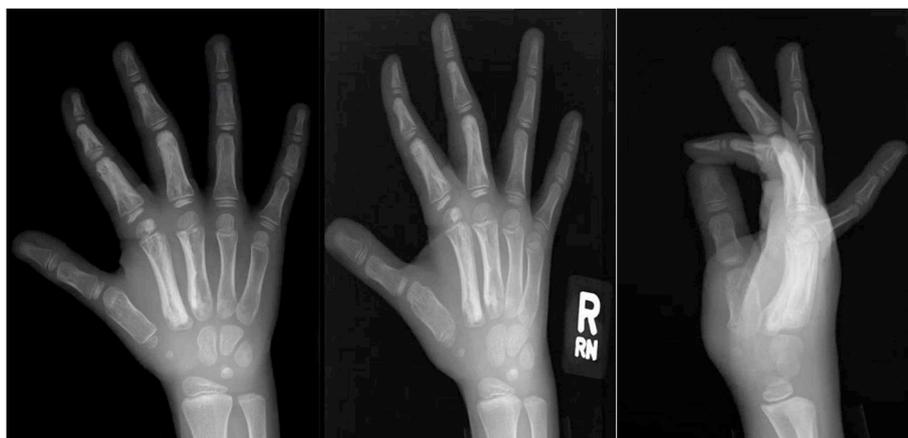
A, B, C. Radiographs of a skeletally immature right hand with (A) anteroposterior, (B) oblique, and (C) lateral views demonstrating melorheostosis of cortical borders of the 2nd and 3rd metacarpals, as well as involvement of the proximal, middle, and distal phalanges of the 2nd and 3rd digits.
